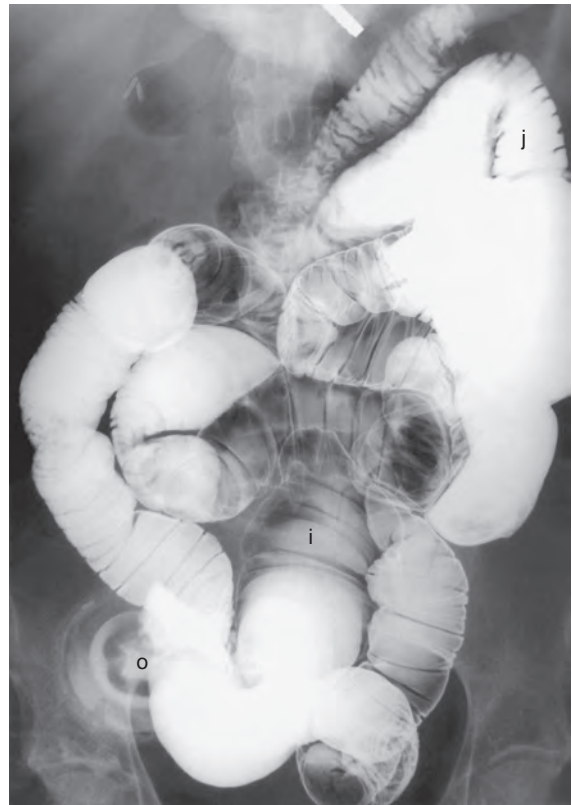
Ileostomy enema. This patient complained of abdominal pain and distention. A total colectomy had previously been performed. CT revealed a dilated small bowel. An overhead radiograph obtained at the end of a retrograde ileostomy enema shows diffuse dilation of small bowel to the level of the proximal jejunum (j). No site of narrowing or obstruction is identified in this patient with an intestinal adynamic ileus. Air-contrast effect in the ileum (i) results from air present in the small bowel before barium was instilled via the ostomy (o).
